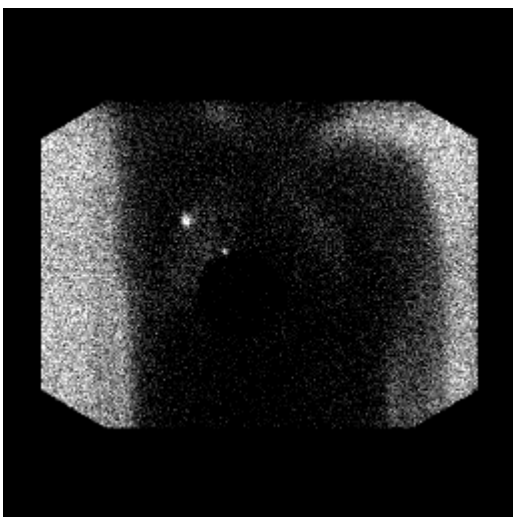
Lymphoscintigram using 0.479 mCi, technetium 99m sulfur colloid for the patient in Case 2. There is one distinct area of increased uptake in her right axilla, representing a sentinel node, and another focus of uptake in her breast, representing the injection site.
